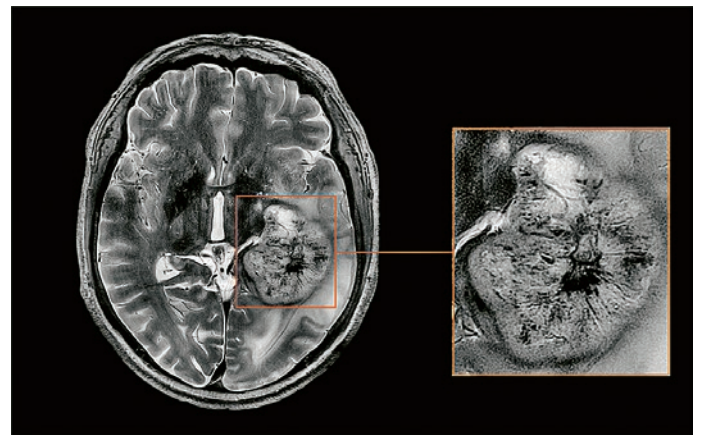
Display of glioblastoma vascularization on 7T MRI
